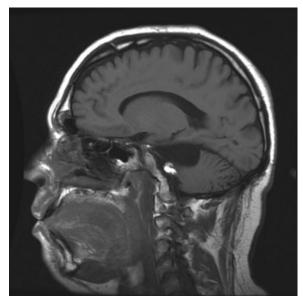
Lipoma. A 28-year-old man was referred with a recurrent cyst in the left cerebellopontine angle. He complained of headache, left-sided hearing loss, dizziness, and vision and balance problems. He had a left-sided abducens palsy. Cyst removal had been performed three times previously, but after all operations a small tumor in relation to the cyst was visible on control magnetic resonance imaging. Unenhanced T1-weighted magnetic resonance imaging showed a large cyst in the left CPA and a hyper-intense tumor in relation to the cyst and pons. The cyst and tumor were removed by the retrosigmoid approach.
